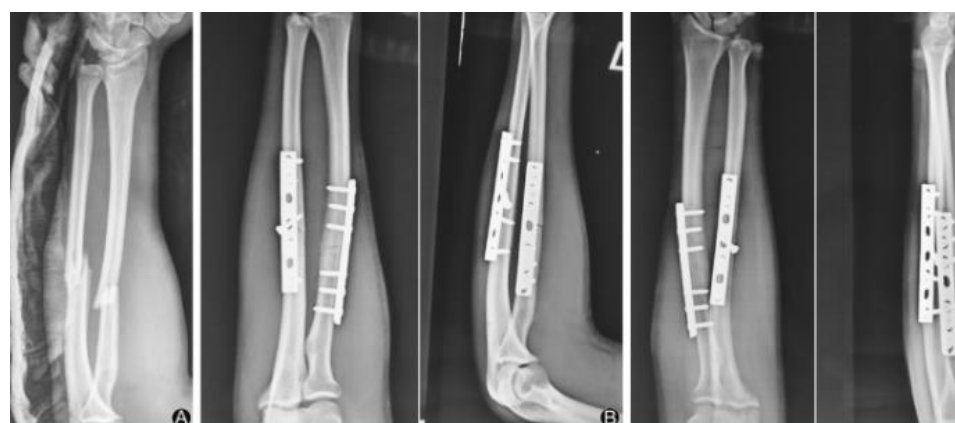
Preoperative radiograph showing radial shaft fracture in the proximal third
